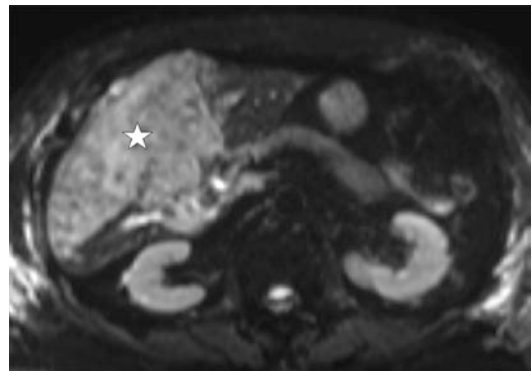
Axial diffusion weighted imaging (DWI) through the level of the liver demonstrating hyperintense (bright) territory within the liver (star)
